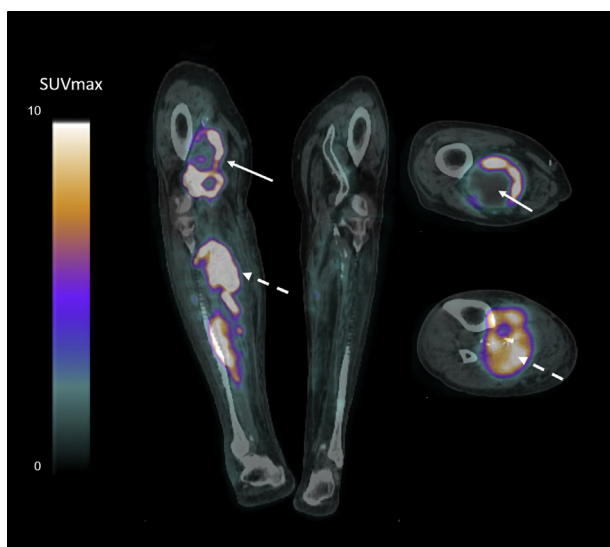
Coronal and axial slices of ^{18}F -FDG-PET imaging showing a particular pattern of intense circular uptake within the arterial wall in a right popliteal aneurysm (white solid arrow) and, additionally, a large hypermetabolic mass in the right leg muscles centered by the graft (white dotted arrow). ^{18}F -FDG, ^{18}F -Fluorodeoxyglucose; PET, positron emission tomography.
